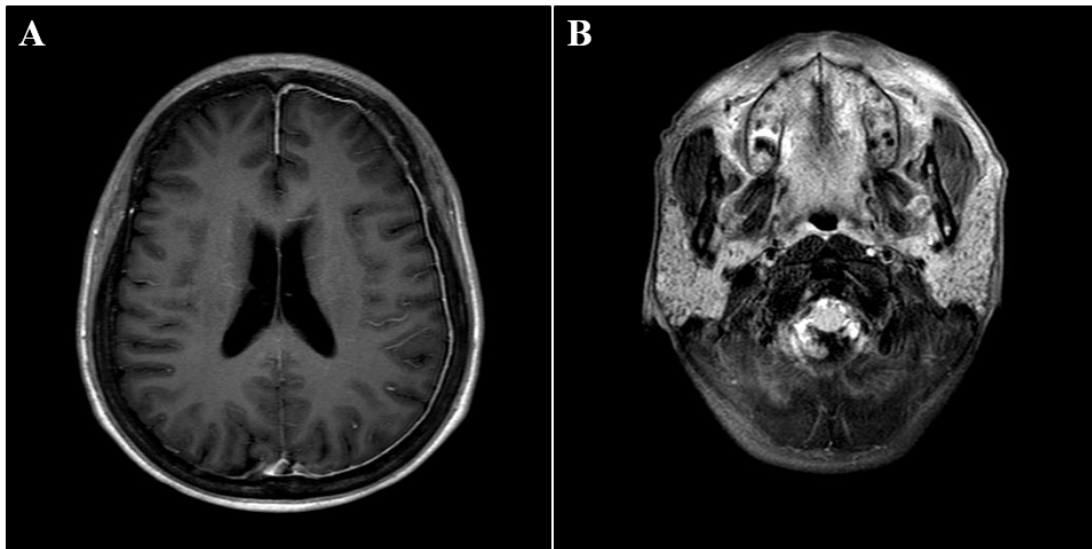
Patient's Magnetic Resonance Imaging (MRI). (A) MRI with gadolinium enhancement reveal hypertrophic enhancement of the pachymeninges in the left cerebral convex. (B) T2-weighted image showing diffuse enlargement of the lacrimal and parotid glands.
